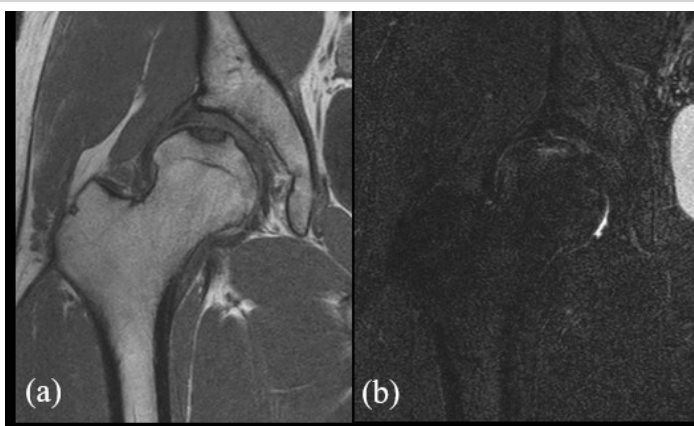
Pre-operative hip magnetic resonance imaging. The femoral head showed low-intensity signal on T1-weighted images and high-intensity signal on T2-weighted images, for which a subchondral fatigue fracture with depression was diagnosed. (a) Coronal T1-weighted image (b) Coronal T2-weighted fat-suppressed image.
